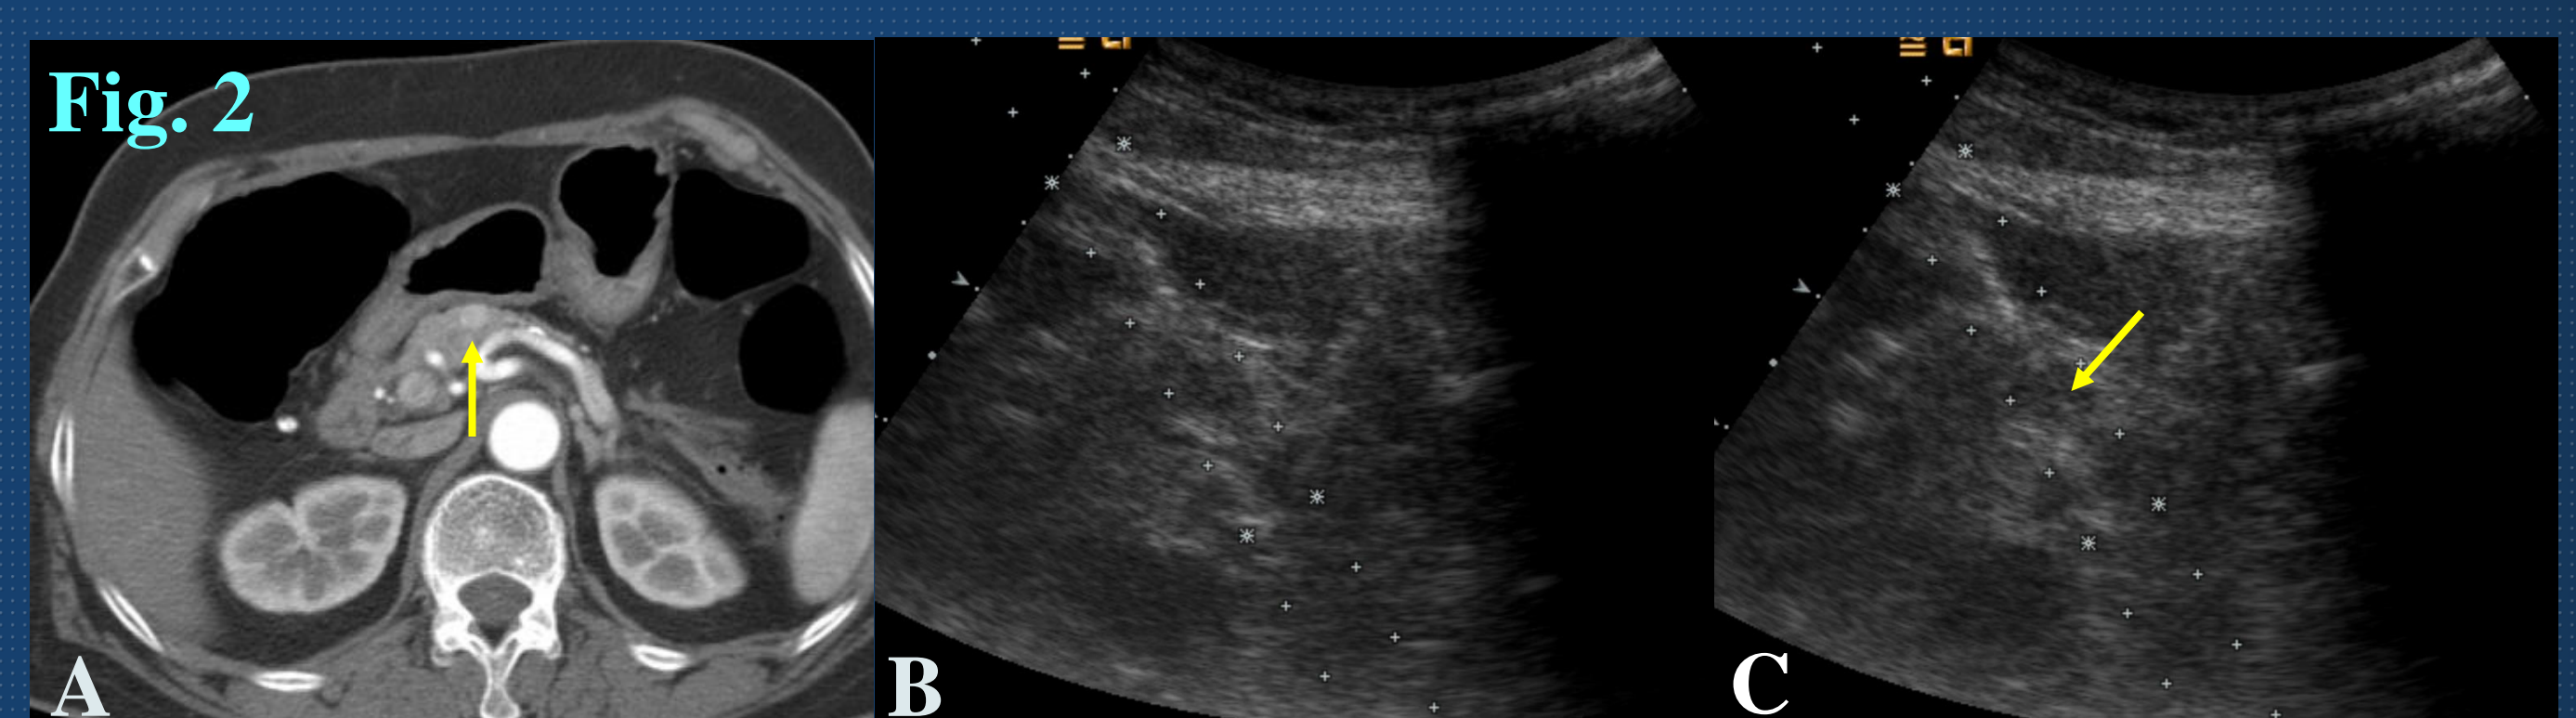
A 70-year-old female patient with NET G1 (A) CT image shows small hypervascular mass in pancreas head. Transverse sonogram shows a small hypoechoic mass in the head of the pancreas. Pre-firing(B) and post-firing(C) sonogram shows the echogenic needle in the mass (yellow arrow). Pathology confirmed an NET G1.
